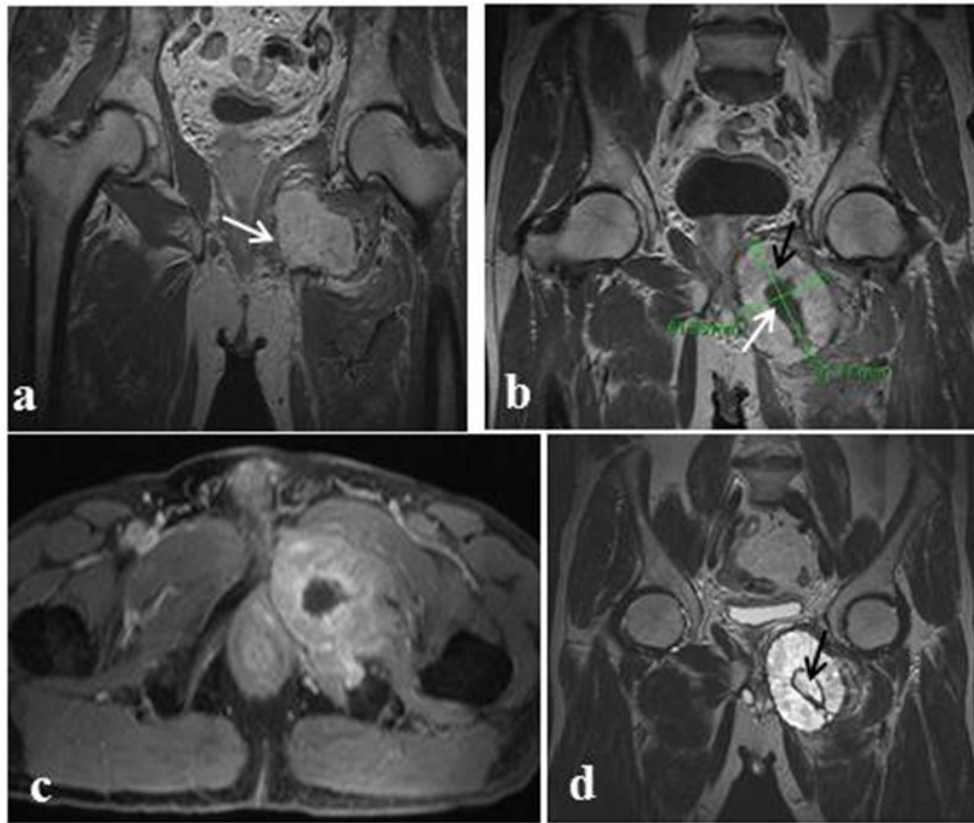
MRI scan. a), b) Gadolinium-enhanced coronar T1-weighted image of ovoid lobulated metastatic PGL lesion (arrow) with typical multiple serpentinosis areas and so-called flow voids – the high vascularization inside the tumor. b) Postcontrast high vascularization in the periphery (black arrow) with higher signal and with central avascular necrosis (white arrow) of the tumor. c) Poscontrast axial T1-weighted image of metastatic lesion in the ramus inferior of os pubis I. sin. Spread of the tumor through foramen obturatum and infiltration of muscular structures of the proximal part of the left hip is seen. d) Coronar T2-weighted image showing a hyperintensive signal with central necrosis and a hemosiderin margin inside the lesion (arrow).
